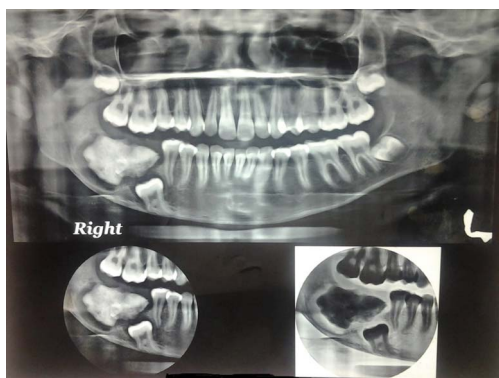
Panoramic radiograph showing mixed radio-opaque mass with a radiolucent rim associated with impacted mandibular molar.
